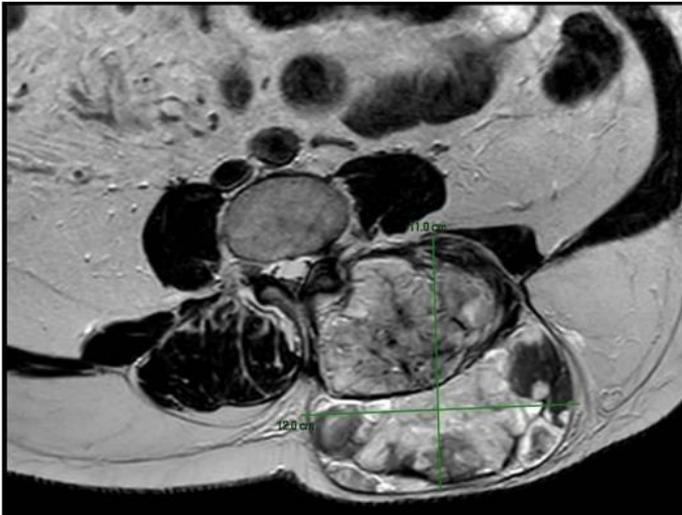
MRI shows large heterogeneous mass in the posterior paravertebral soft tissues on the left side, extending from T12 to S1 levels, measuring approximately 20 x 12 x 11 cm in maximal craniocaudal, transverse, and anteroposterior dimensions, respectively
